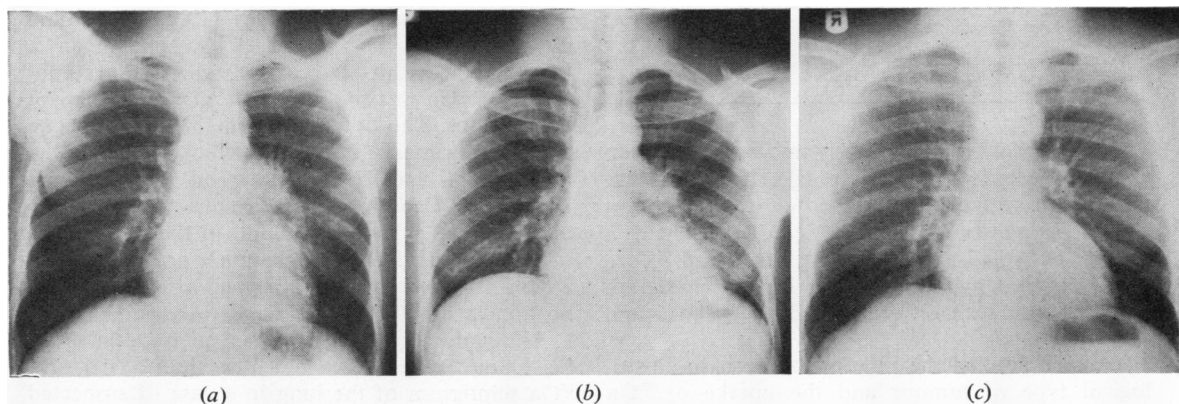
Male patient aged 27 years. Primary tuberculosis of the lungs with enlarged left hilar lymph nodes: Chest radiographs (a) before treatment; (b) after two months' tuberculostatic treatment; (c) after seven months' tuberculostatic treatment.
